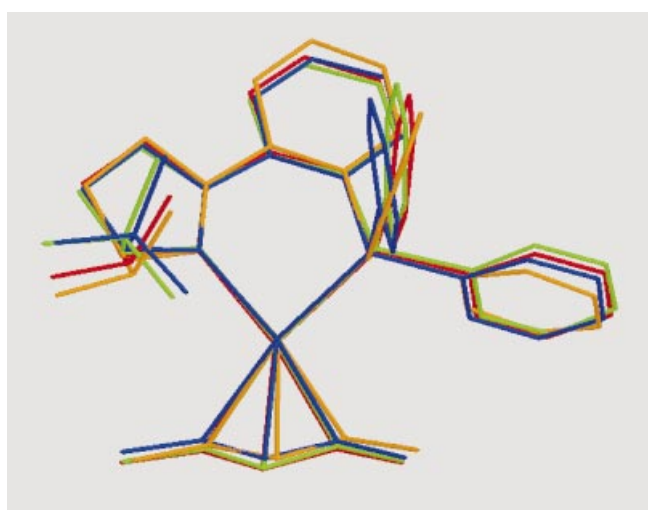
Comparison of structures obtained by X-ray structure analysis and ab initio calculations; 6xss: calculated (red), X-ray (orange); 7xss: calculated (green), X-ray (blue).
